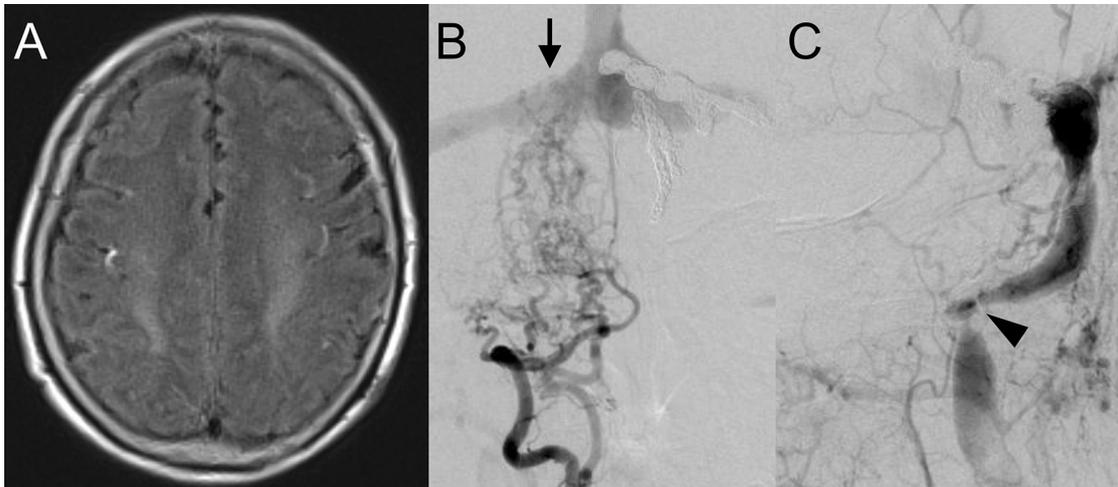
(A) MR image (FLAIR) before 3rd intervention showing extensive cortical edema in the bilateral cerebral hemispheres. (B) Frontal projection of right vertebral artery (VA) angiogram (early arterial phase) showing that d-AVFs at the sinus confluence and the medial portion of right TS (arrow) are fed by the multiple feeders from muscular branches and the posterior meningeal artery of the right VA. Aggravation of these d-AVFs are also noted. (C) LAO projection of the left ECA angiogram (late arterial phase) demonstrating progressive stenosis of the left jugular bulb (arrowhead). d-AVF: dural arteriovenous fistula; ECA: external carotid artery; LAO: left antero-oblique; TS: transverse sinus
